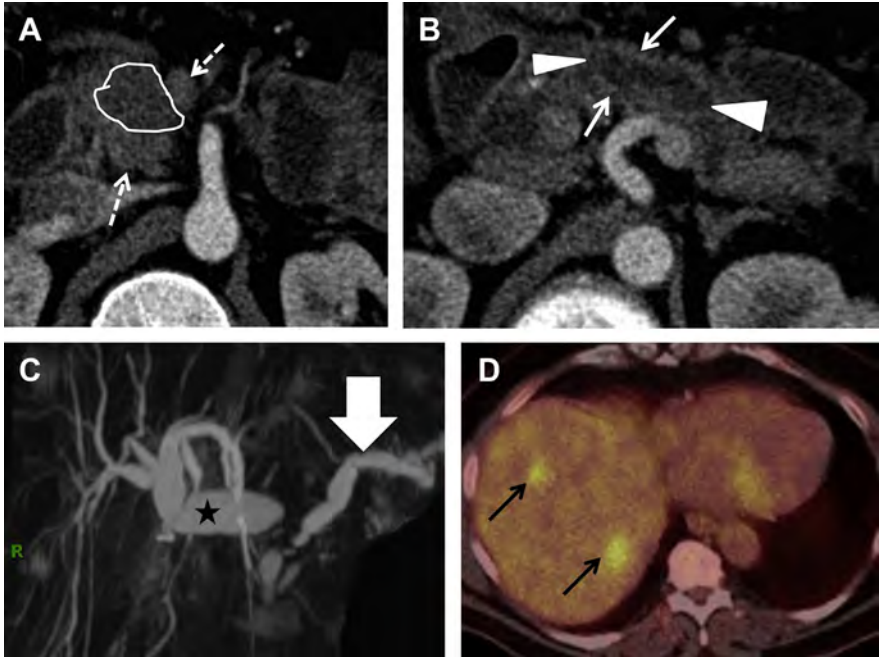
Pancreatic phase axial CT scan through the level of the pancreatic head shows a mass that is hypodense (*outline*) compared with the background pancreas (*dashed arrows*) (A). Axial image from the same patient at a different level shows markedly dilated pancreatic duct (*arrowheads*) and atrophic pancreatic parenchyma in the body and tail (*arrows*) (B). Maximum intensity projection image from MRCP shows the “double duct sign,” with markedly dilated common bile duct (*asterisk*), intrahepatic ducts, and pancreatic duct (*arrow*) (C). Axial PET-CT image from a different patient with pancreatic cancer shows FDG-avid liver metastasis (*arrows*) (D).
